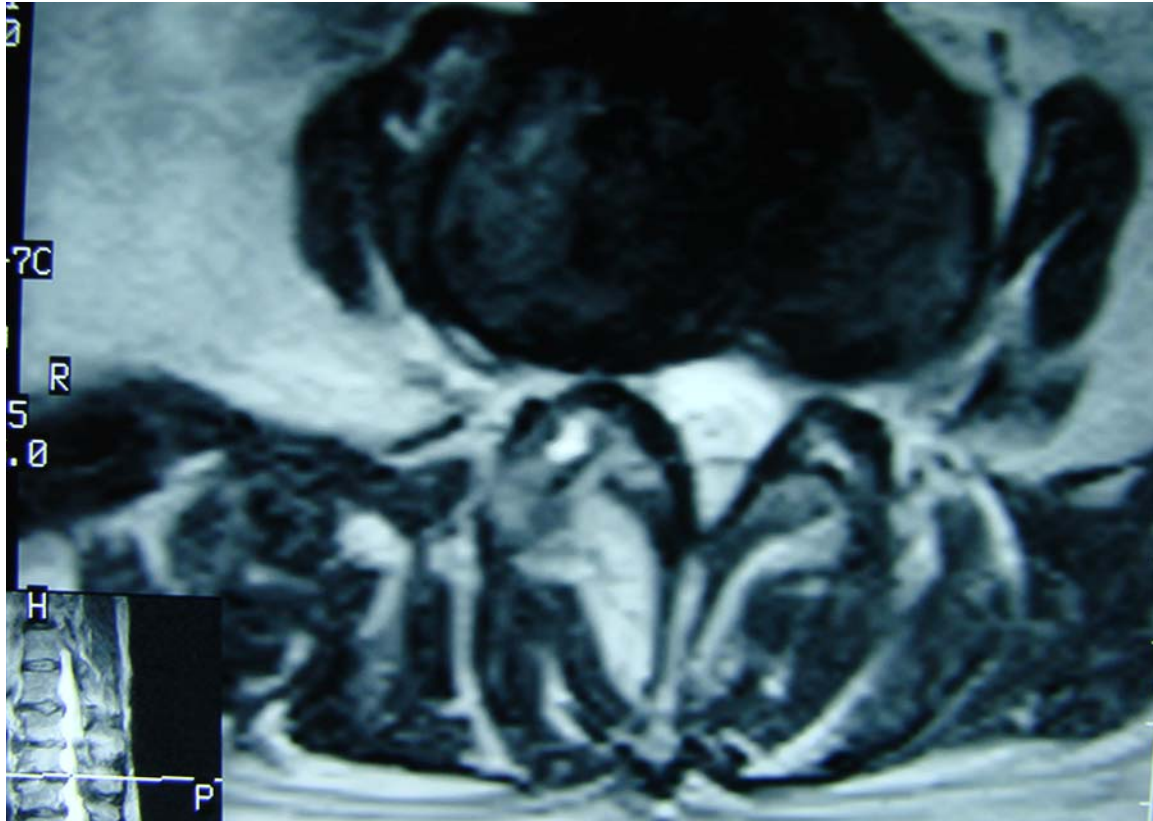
is an axial MRI image at the L3-L4 level showing endplate hypertrophy causing bilateral osseoligamentous foraminal stenosis with facet arthrosis and ligamentum flavum hypertrophy resulting in posterior and lateral stenosis of the vertebral and osseoligamentous canals. Hyperintensity within the bilateral facet joints and ligamentum flavi are noted suggesting synovial cyst change.
